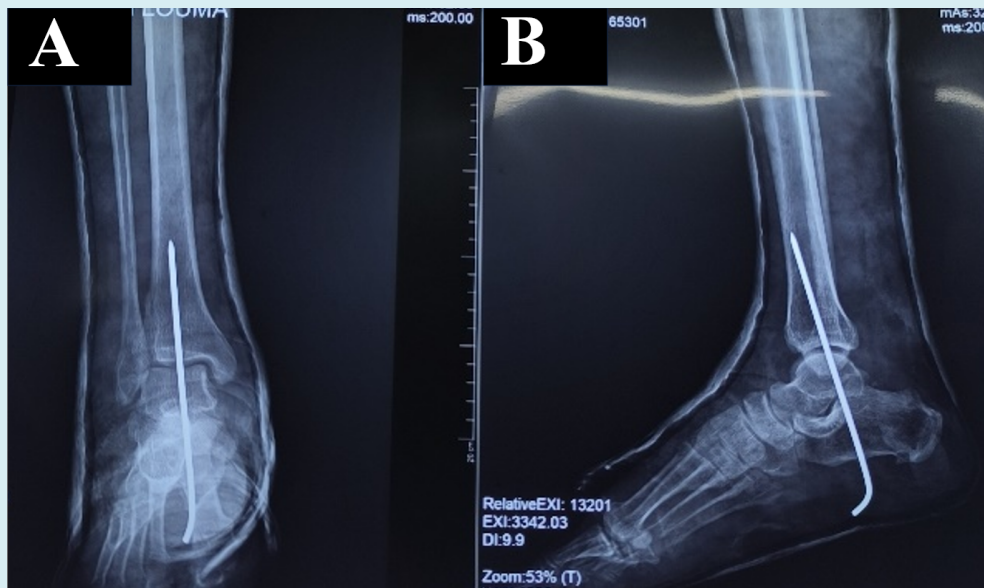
Standard postoperative radiographs of the left ankle, front (A) and side (B) after reduction and pinning.
